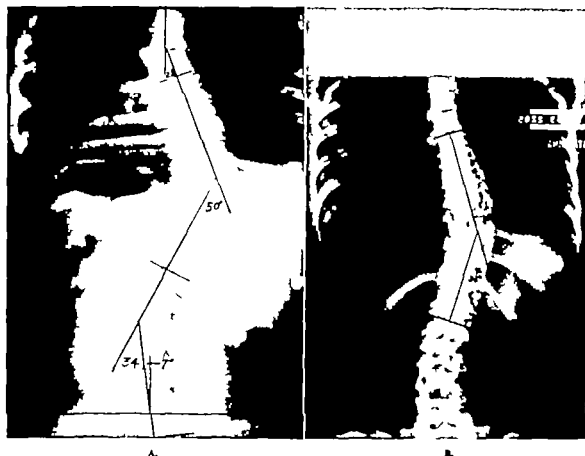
A, Roentgenogram of an idiopathic scoliosis before fusion. B, Roentgenogram of the same patient six years after fusion. (From Schmidt, A. G. Verhandl. deutsch. orthop. Gesellsch., 41 Kongress, pp. 195-220 1954 Ferdinand Enke Verlag Stuttgart.)
